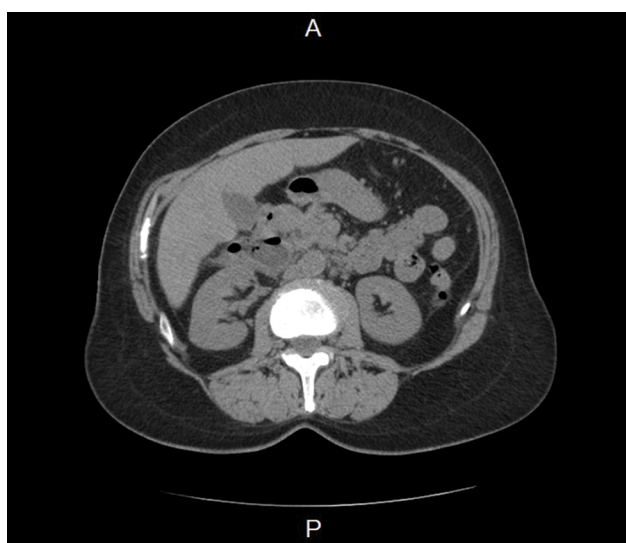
CT scan without contrast. The CT scan revealed free air and liquid around the second part of the duodenum, findings suggestive of duodenal perforation.
